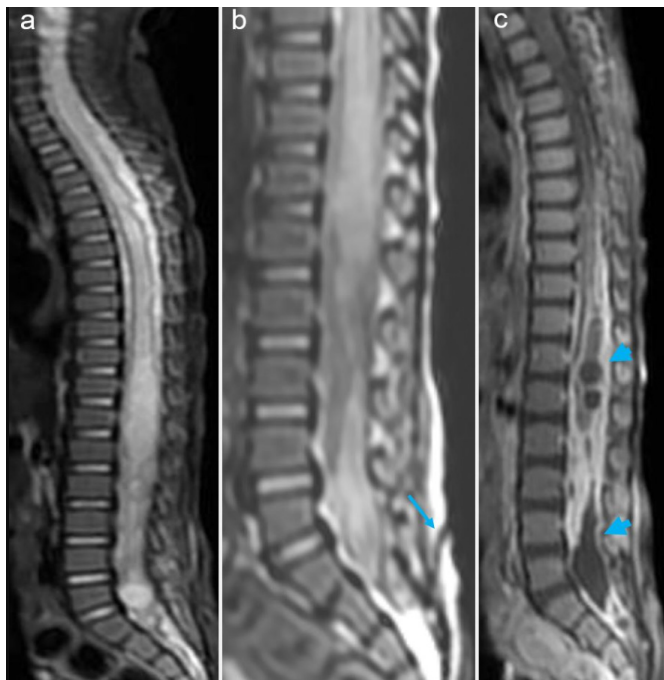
a, b. Sagittal T2-weighted and short tau inversion recovery (STIR) images show a diffuse signal increase and expansion in the spinal cord, consistent with myelitis. The sagittal T2-weighted image also demonstrates dermal sinus tract (long arrow) at the S1-S2 level. c. Sagittal contrast-enhanced T1-weighted image demonstrates interconnected fluid collections with rim enhancement within the spinal cord (arrowheads) and thick enhancement on dura between T7-S2 levels. This appearance is consistent with spinal meningitis and abscess.
